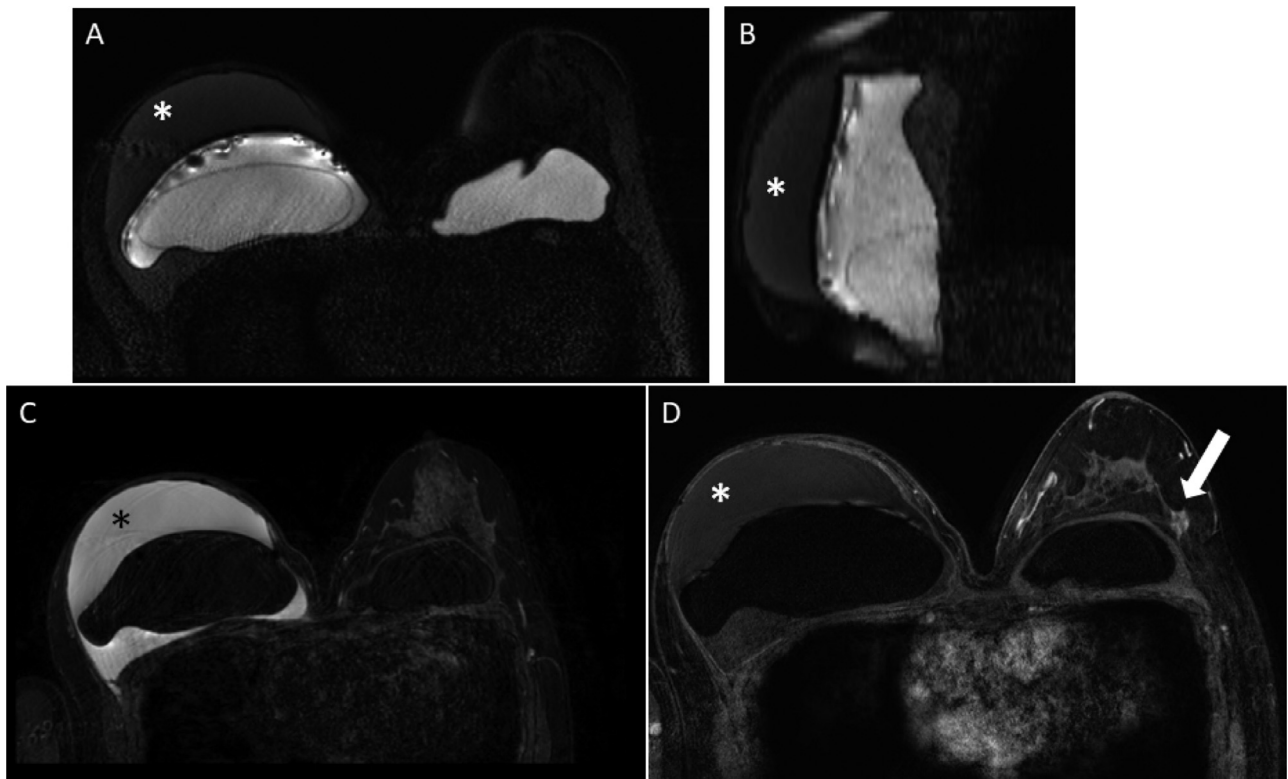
Bilateral breast MRI with (A) axial and (B) right breast sagittal silicone-sensitive images, (C) axial T2-weighted SPAIR image, and (D) axial T1-weighted fat-saturated postcontrast image. The patient had prior right mastectomy. There is an intact double-lumen silicone right breast implant and an intact single-lumen silicone left breast implant. A large peri-implant fluid collection is present on the right (asterisks) and there is focal nonmass enhancement in the left breast (arrow).
